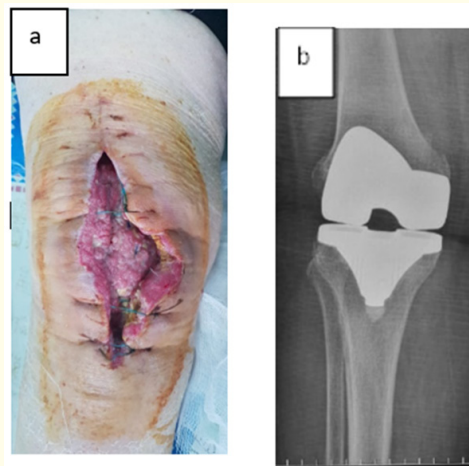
Photo of a wound and X-ray at T₀, clinical case 2.
